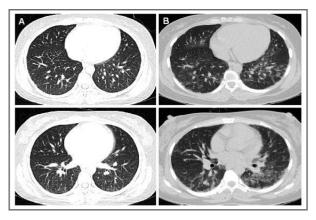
Radiological evolution of lung CT scan. (A) At the time of diagnosis, CT scan showed interstitial ground-glass opacity in the bases and inferior lobes with peripheral distribution. (B) 25 days later, CT scan images demonstrated an important progression of the lung lesions and areas of fibrosis and honeycomb in both lung bases
